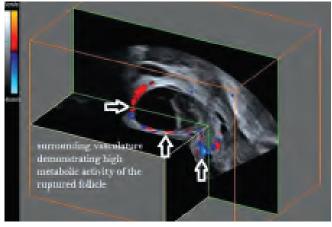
Three-dimensional color Doppler ultrasound. Using niche image, capillaries invading the blood filled cavity of the follicle are clearly visualized
